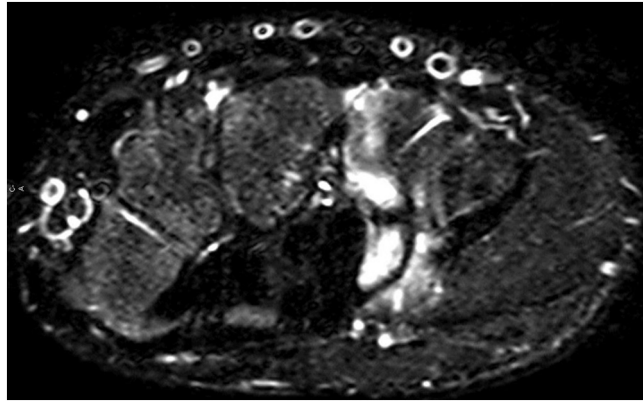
Preoperative MRI view of left wrist demonstrates the nonunion of the hook of hamate fracture with associated bone edema.
